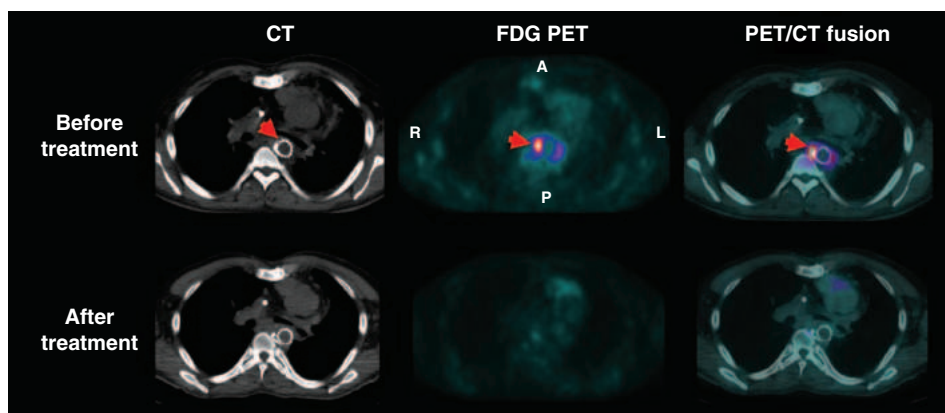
Representative cross-sectional computed tomography (CT; *left*), fluorodeoxyglucose (FDG) positron emission tomography (PET; *middle*), and fused CT and PET (*right*) images before and after antibiotic treatment in a patient with fever and suspected infection of the stent placed in the descending portion of the aortic arch (*arrow*) for treatment of aortic coarctation. The FDG images before treatment demonstrate intense glucose uptake within the stent, consistent with inflammation/infection. The *lower panel* demonstrates significant attenuation of the FDG signal after treatment. (Images used with permission from Dr. Sharmila Dorbala, Brigham and Women's Hospital.)
